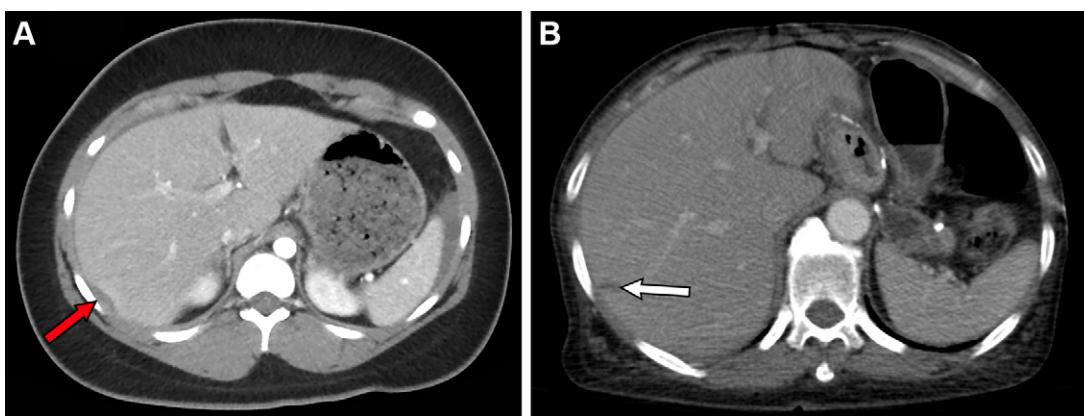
Grade I liver injuries according to the revised 2018 AAST-OIS. (A) Axial contrast-enhanced CT image in a 21-year-old woman after a motor vehicle collision shows a small subcapsular hematoma (arrow) along segment VI, measuring 2.2×0.7 cm (<10% of the liver surface) with no associated hepatic laceration. The patient also suffered a bucket handle omental injury with arterial bleeding (not shown), which required exploratory laparotomy and omentectomy. The subcapsular hematoma was successfully managed conservatively. (B) Axial contrast-enhanced CT image in a 48-year-old woman after a motor vehicle collision shows a hepatic laceration measuring less than 1 cm in depth (arrow). An axial cine clip of this patient is shown in Movie 6.
